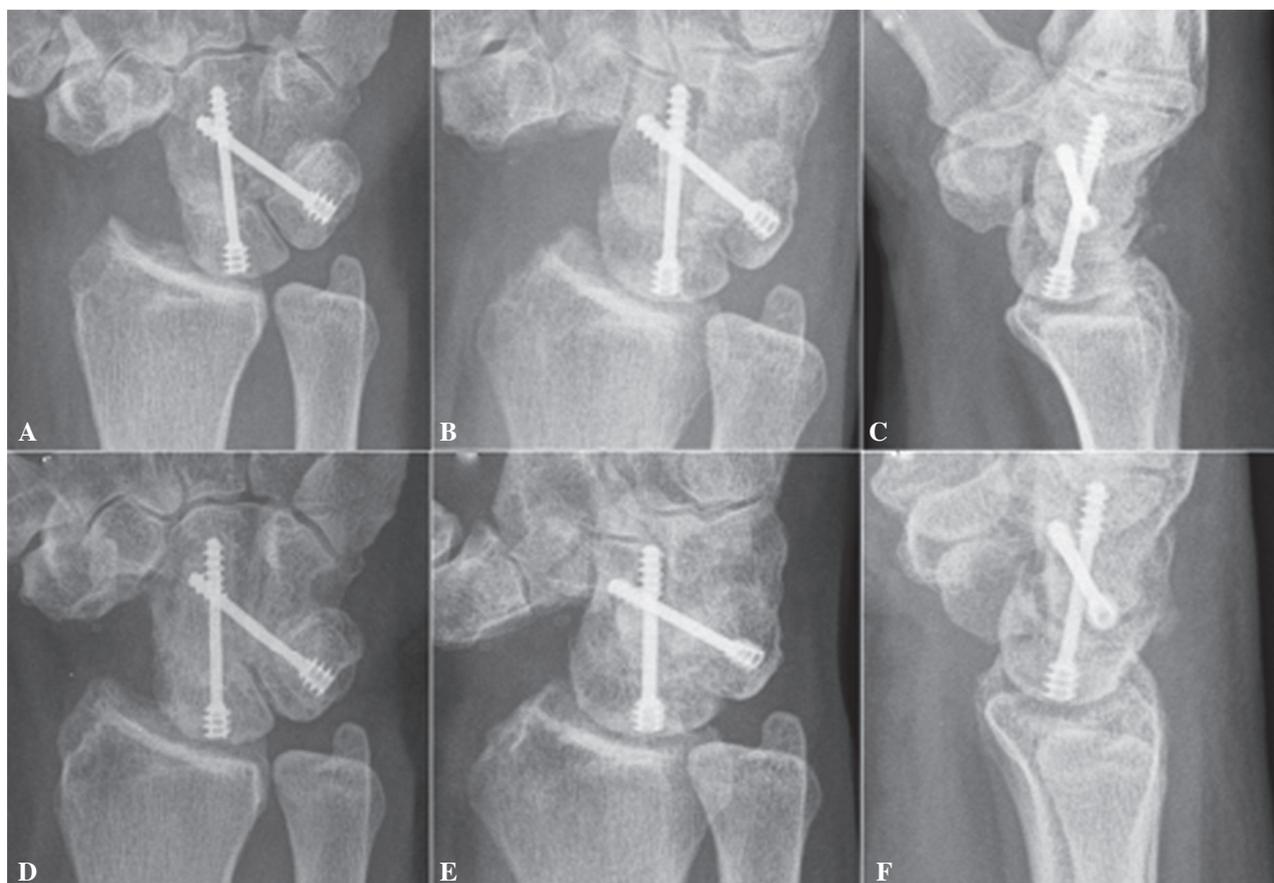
Antero-posterior (A), oblique (B), and lateral (C) x-rays obtained at 7 weeks postoperatively. One reviewer interpreted the series as fused, and two interpreted it as not fused. At the last follow-up, at 636 days postoperatively (D, E, F), all three reviewers interpreted the series as fused.
